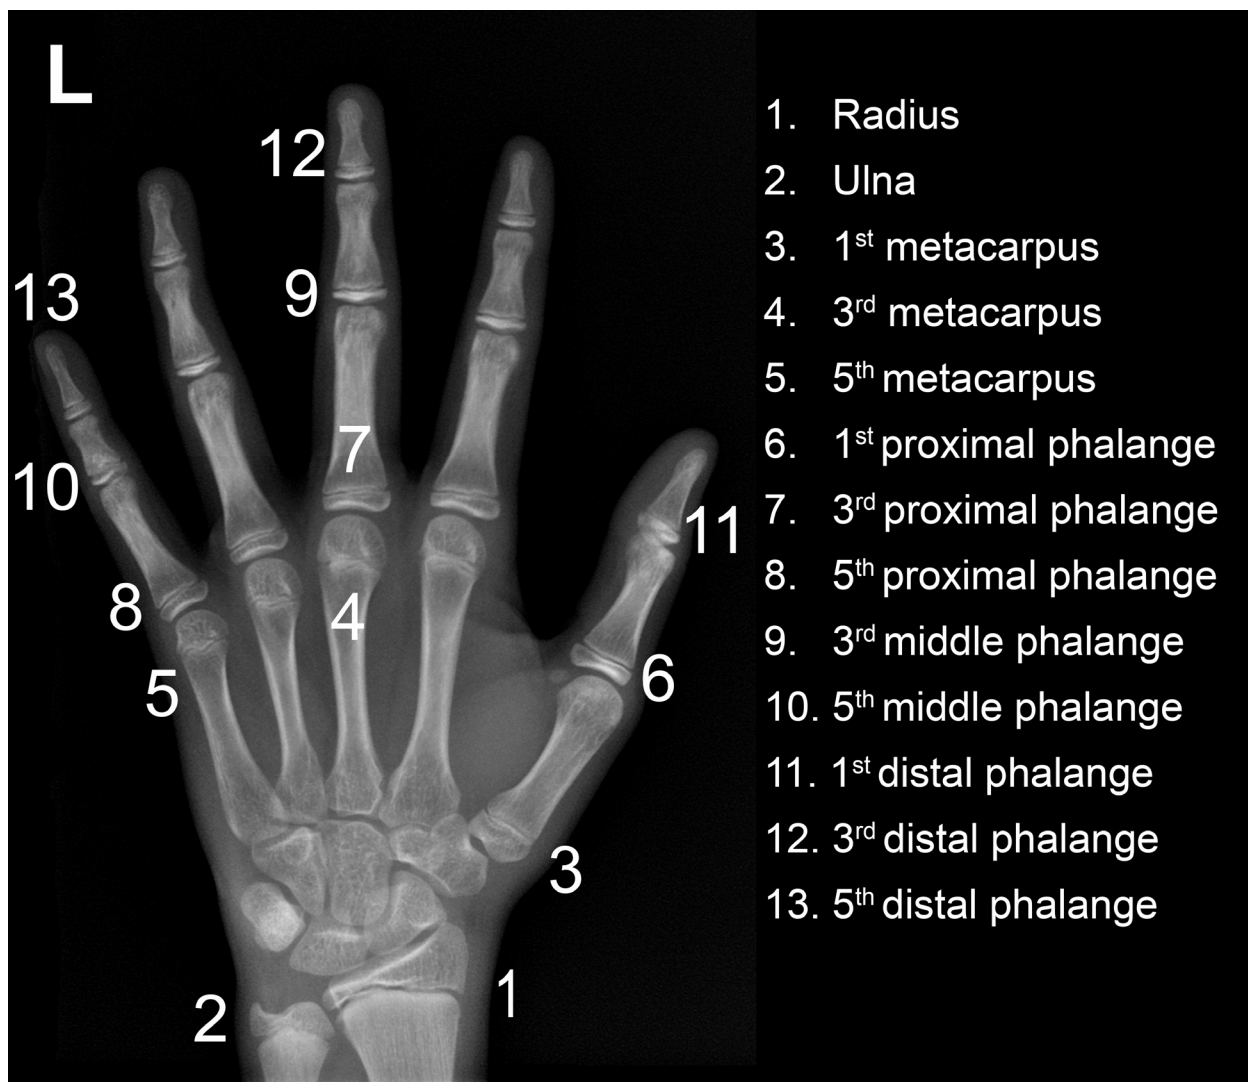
An example of hand and wrist radiograph, showing 13 regions of interest of the hand and wrist bones according to Tanner and Whitehouse 3 (TW3-RUS) method. Each number referred to each bone: 1, Radius; 2, Ulna; 3, 1st metacarpus; 4, 3rd metacarpus; 5, 5th metacarpus; 6, 1st proximal phalange; 7, 3rd proximal phalange; 8, 5th proximal phalange; 9, 3rd middle phalange; 10, 5th middle phalange; 11, 1st distal phalange; 12, 3rd distal phalange; 13, 5th distal phalange. Stages based on TW3 definitions were given to each region and then translated to RUS scores (Table 1). Sums of the scores were then converted to age
